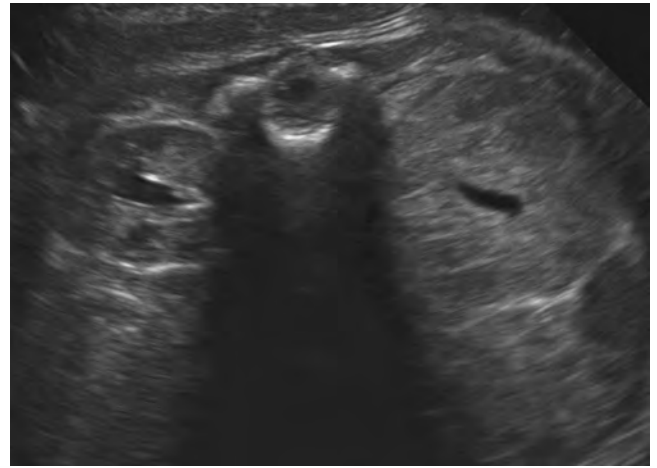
Antenatal ultrasound image at 38 weeks' gestation demonstrates an enlarged left hyperechoic kidney with loss of corticomedullary differentiation.
